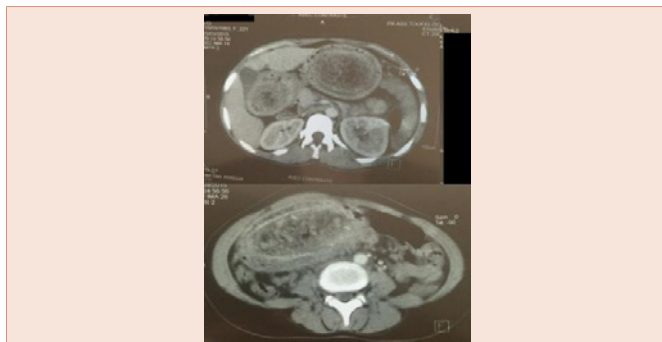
Axial computed tomography image at the level of the gastric body demonstrating a mass with “entangled appearance” occupying the whole lumen.
